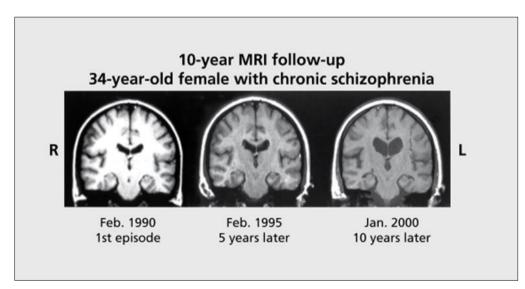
10-year brain MRI follow-up of a schizophrenia patient
